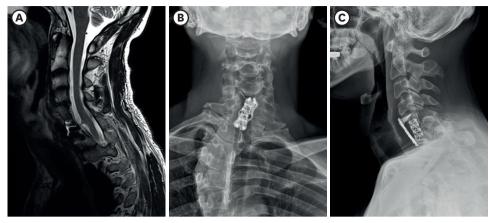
Two months follow up T2-weighted magnetic resonance images (A) demonstrate total neurenteric cyst removal; C-spine anterior (B) and lateral (C) radiograph of cervical spine demonstrating C56 corpectomy.
